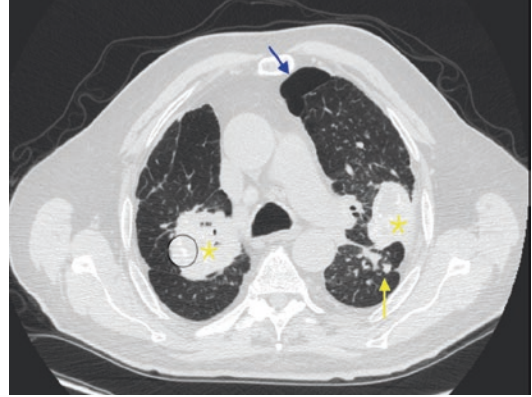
Axial image from a thin-section unenhanced CT scan (1.0-mm-thick section) shows multiple nodules ranging between 5 mm and 4 cm (yellow arrow) with a perilymphatic (centrilobular plus subpleural) distribution in the upper lobe of both lungs (yellow arrow and star). They demonstrate a tendency toward coalescence of the nodules in the lung periphery (yellow arrow). It is possible to highlight the presence of coarse calcification of the biggest nodule (magnified). Paraseptal emphysema is also seen (blue arrow)
